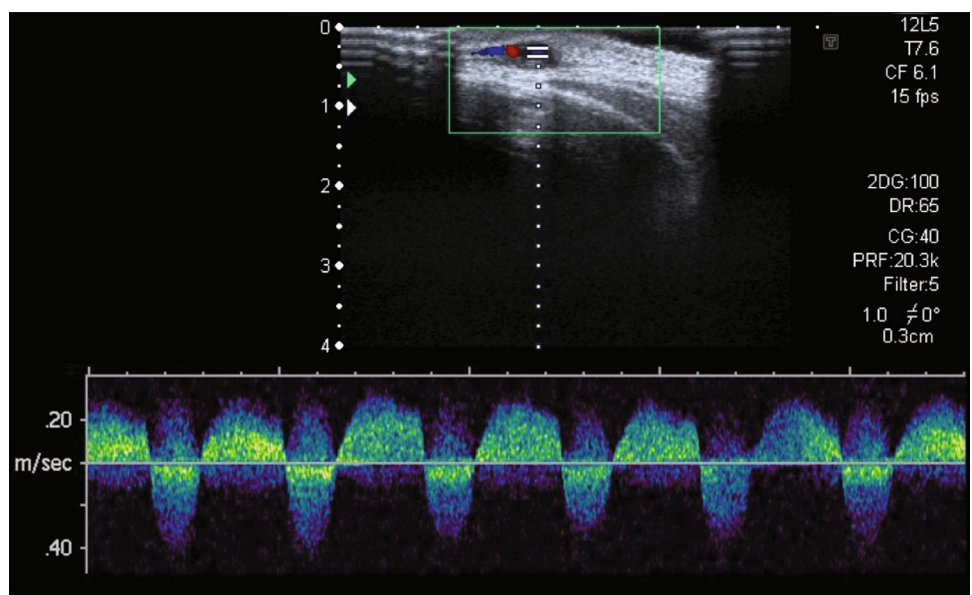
B- and Doppler mode images of superficial swelling in left temporal region of a 25 years-old man with trauma history 6 months prior. a B-mode image shows an *oval*-shape hypo-anechoic lesion with mural mildly echogenic trombus. b Colour-Doppler US image demonstrating a bidirectional swirling flow (“yin and yang appearance”) in the lesion consistent with a pseudoaneurysm
